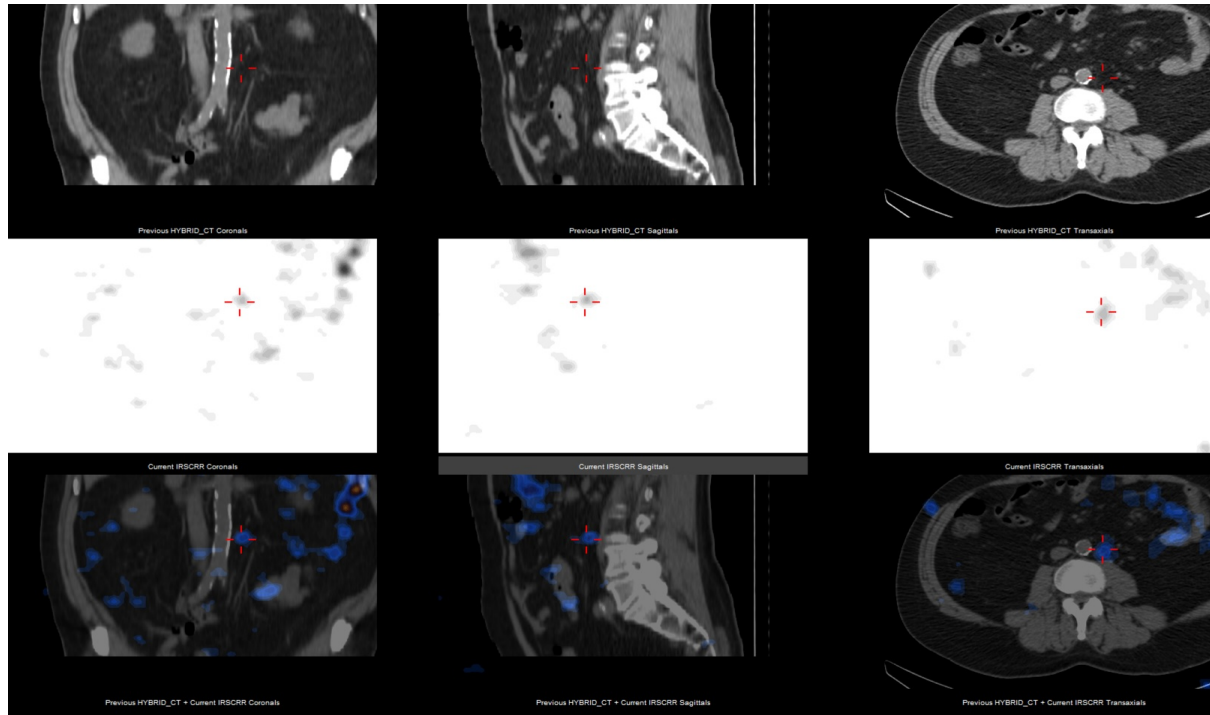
Planar and SPECT imaging over coronal, sagittal and axial planes depicting an IMA DLP in Patient 8, who underwent water-jet massage following SF injection. The crosshairs are centred over a LN with focal uptake, located in the para-aortic area along the IMA trajectory.
